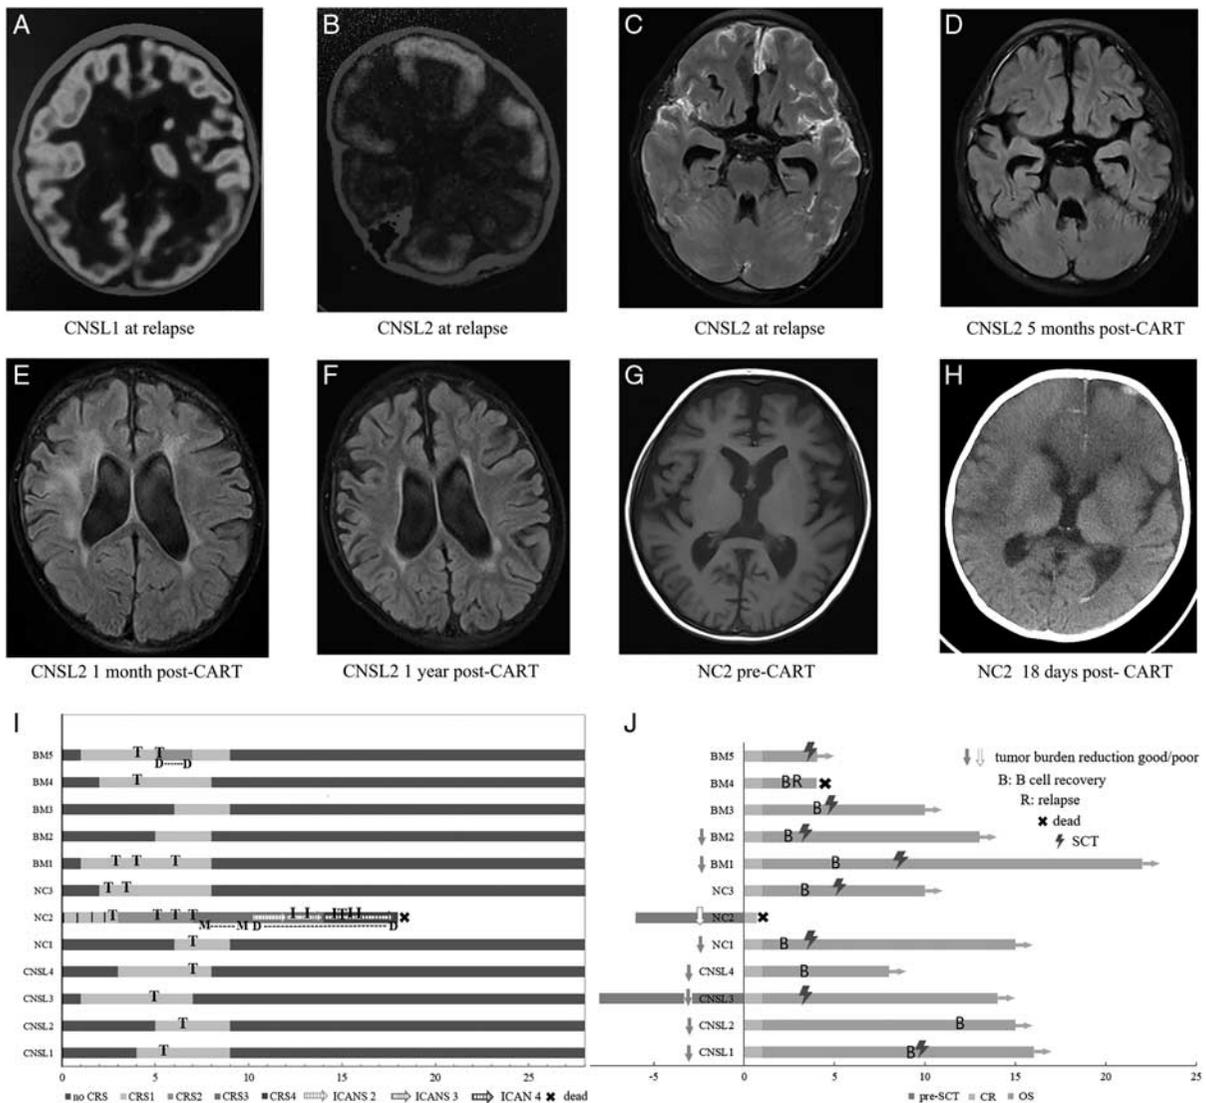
Imaging findings for patients with CNSL or neurological comorbidity and overall survival after CAR-T therapy. A, 18F-FDG metabolism on PET-CT was obviously increased in the left lateral fissure meninges in patient CNSL1 at relapse. B, Diffuse uneven FDG metabolism was abnormally elevated in the left cerebral cortex of patient CNSL2 at relapse. C, Extensive leptomeninges infiltration with hyperintensity and encephalomalacia with hypointensity in the frontal lobe on enhanced T2-FLAIR images in patient CNSL2 at relapse. D, Leptomeninges lesions disappeared after CAR-T therapy on enhanced T2-FLAIR images in patient CNSL2. E, Extensive white matter hyperintensities on T2-FLAIR imaging in patient CNSL2 at 1 month after CAR-T infusion. F, The near complete resolution of white matter hyperintensities after 1 year post CAR-T. G, Slight encephalatrophy and ventriculomegaly on T1-weighted images in patient NC2 before CAR-T. H, Severe cerebellar edema and cerebral hemorrhage in the frontal lobe on CT in patient NC2 on day 18 post CAR-T. I, CRS grade of and neurotoxicity graded by ASTCT consensus guidelines. Severity of CRS is represented by color codes and neurotoxicity grade is represented by color arrows. Striped rows represent patients with fever before CAR-T cell administration that did not reflect CRS precisely. Day 0 is the day of cell administration. J, Overall survival after CAR-T therapy. 18F-FDG indicates 18F-fluorodeoxyglucose; BMI, bone marrow relapse; CNSL, central nervous system leukemia; CR, complete remission; CRS, cytokine release syndrome; CT, computed tomography; FDG, fluorodeoxyglucose; ICANS, immune effector cell-associated neurotoxicity syndrome; NC, neurological comorbidity; Pre-SCT, previous stem cell transplantation; OS, overall survival.
